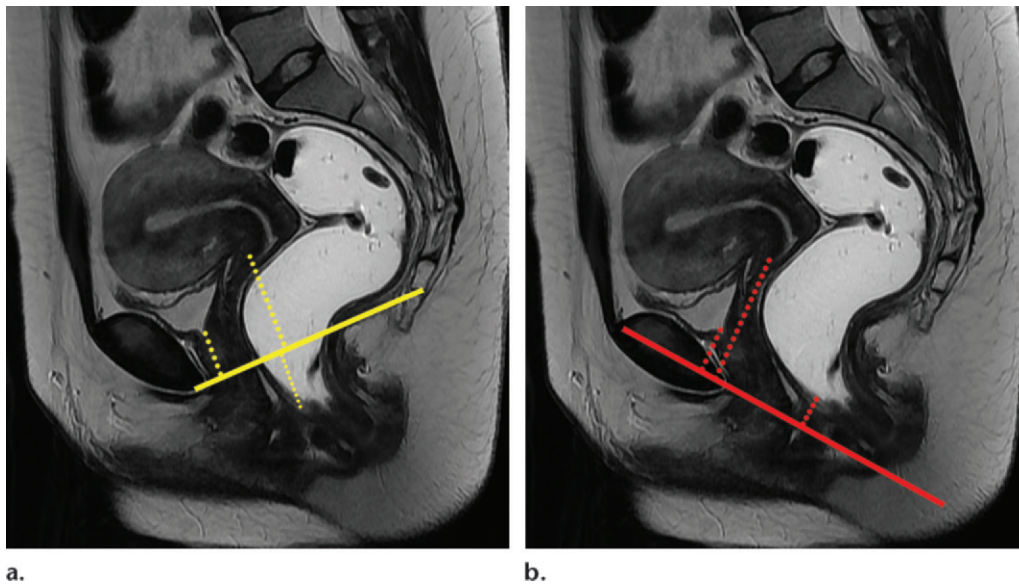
Midsagittal T2-weighted MR images obtained in a female patient with normal anatomy during rest show the reference lines most frequently used for the evaluation of pelvic floor weakness: the PCL (solid line in a) and MPL (solid line in b). Perpendicular dotted lines drawn from anatomic reference points in the anterior, middle, and posterior pelvic compartments to the PCL and MPL for the assessment of organ prolapse also are shown.
